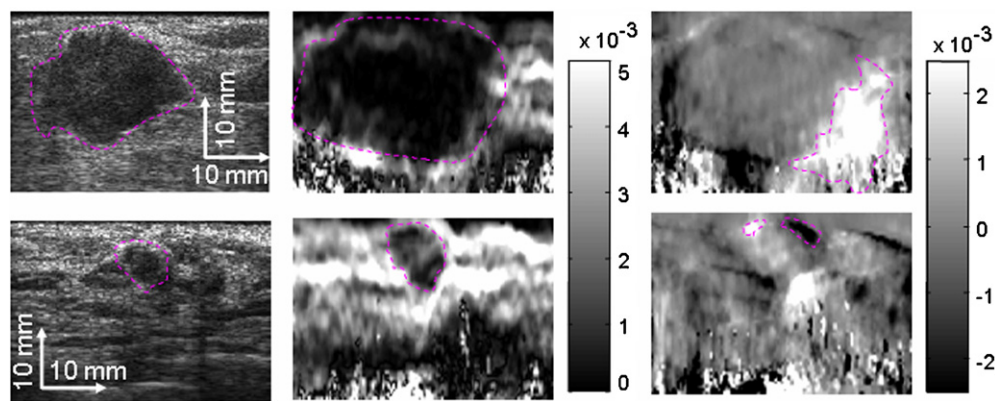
An example of the images used during *observer training*. Sonograms (first column), axial elastograms (second column) and ASSEs (third column) of a cancer (top row) and benign lesion (bottom row) are shown. The applied axial compression strain was 0.25%. Observer's outline (–) of the tumor appearance in sonograms and elastograms is shown. In addition, the observer's outline of the feature in ASSE is also shown.
